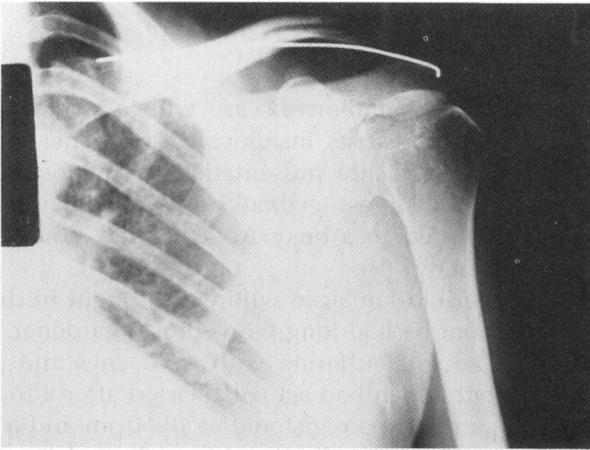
X-ray showing a Kirschner Wire within the clavicle which could not be retrieved
